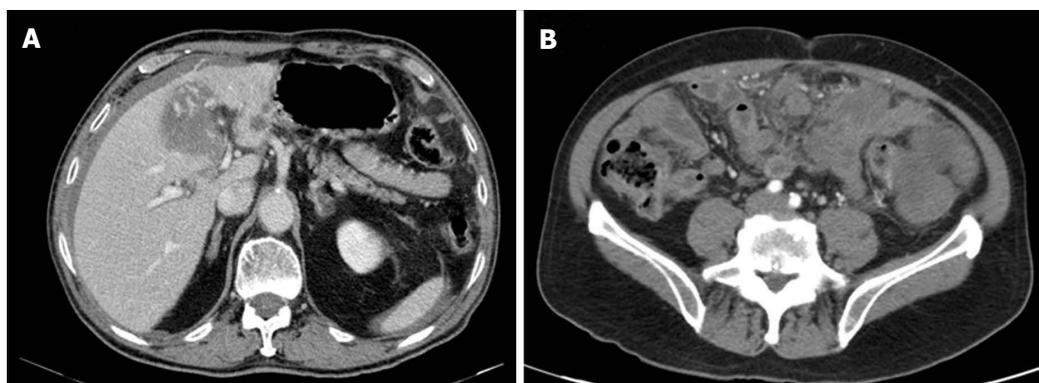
Metastatic gastrointestinal stromal tumors on computed tomography scan. A: Liver metastasis; B: Peritoneal metastasis “Gistosis”. In A, it is appreciated a large hepatic metastasis in segment IV. B shows the CT of a patient with disseminated peritoneal disease “GISTosis”.
